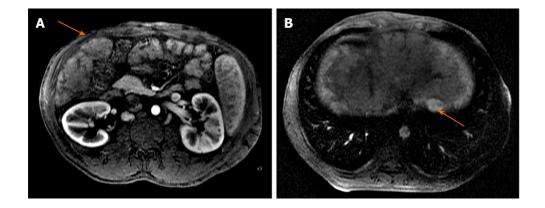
Liver magnetic resonance imaging with hepatobiliary contrast (arterial phase). A: Hypervascularized nodule in segment V of 4 cm (arrow); B: Hypervascularized nodule in segment II of 2.3 cm (arrow).
